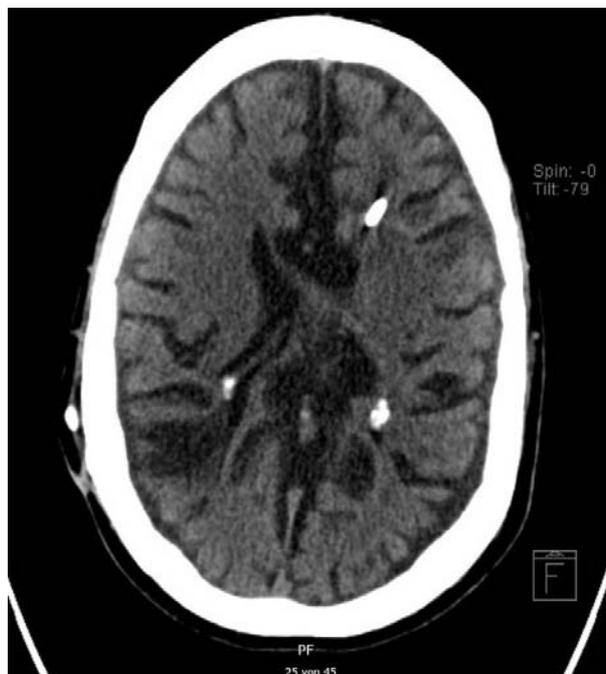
Transverse cranial CT scan of ACM-II malformation
